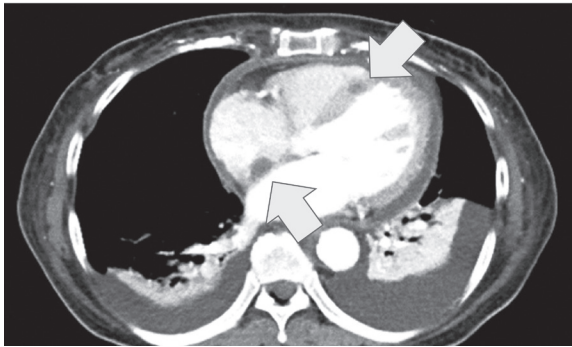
Enhanced abdominal computed tomography scan showing abscesses in ventricular septum and free wall.
